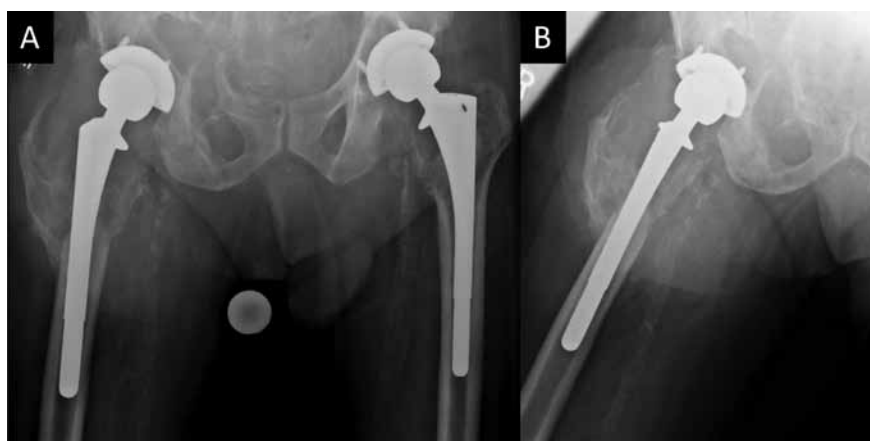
One-year postoperative anteroposterior pelvis radiograph (Fig. 5-A) and frog-leg lateral radiograph (Fig. 5-B).
